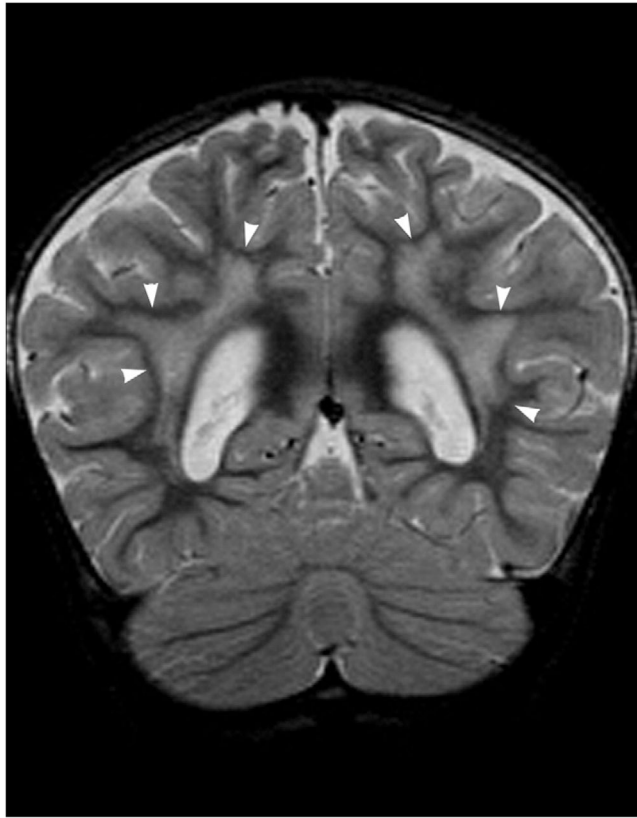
Brain magnetic resonance imaging of patient 1. Coronal T₂-weighted image of the brain demonstrates confluent areas of white-matter T₂ hyperintensity in the bilateral parietal regions, with sparing of subcortical U-fibers (arrowheads). Patchy areas of white-matter signal abnormality are present in the frontal lobes bilaterally, with bilateral ventricular enlargement.
